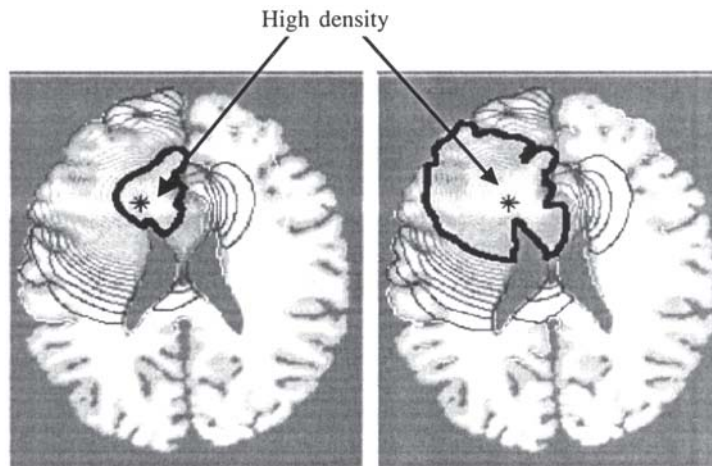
Detection of brain tumour growth using CT scan
